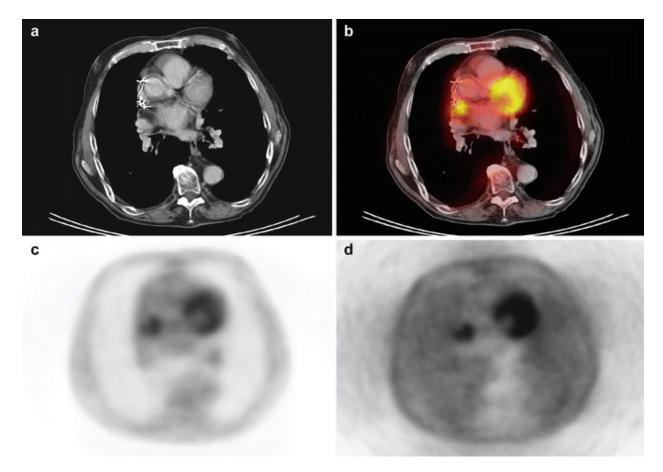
74 year old male patient suffering from metastatic squamous cell carcinoma undergoing PET/CT for whole-body tumor staging. Morphological CT (a), fused PET/CT (b) as well as attenuation corrected (c) and non attenuation corrected (d) PET images are displayed. Increased interatrial fat is observed in morphological CT (a and b) with an increased tracer accumulation that can be observed in the attenuation corrected (c) and non attenuation corrected PET images (d), proving that the increased tracer uptake in the attenuation corrected PET images is not an artifact but indicates a lipomatous hypertrophy of the interatrial septum (LHIAS)
